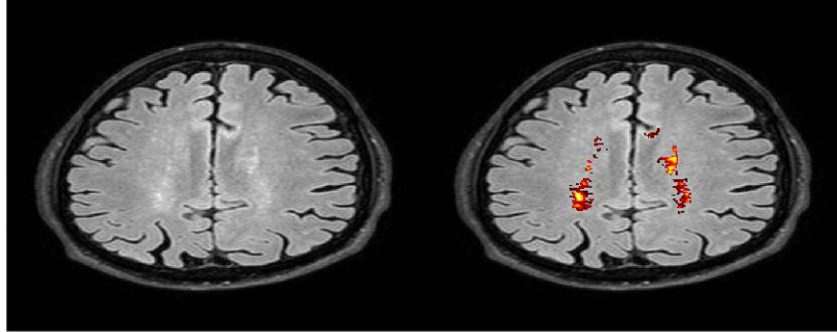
LST-produced FLAIR Image for non-RHI subject.* Axial slice at the level above the ventricles for a non-RHI subject. The subject has no history of CCS. The left image represents the FLAIR image and the right is the overlay of the segmentation of the FLAIR image with WMHs in red and yellow. Most of the WMHs are found periventricularly in this individual. The individual's WMH volume = 4 across 14 total lesions.
